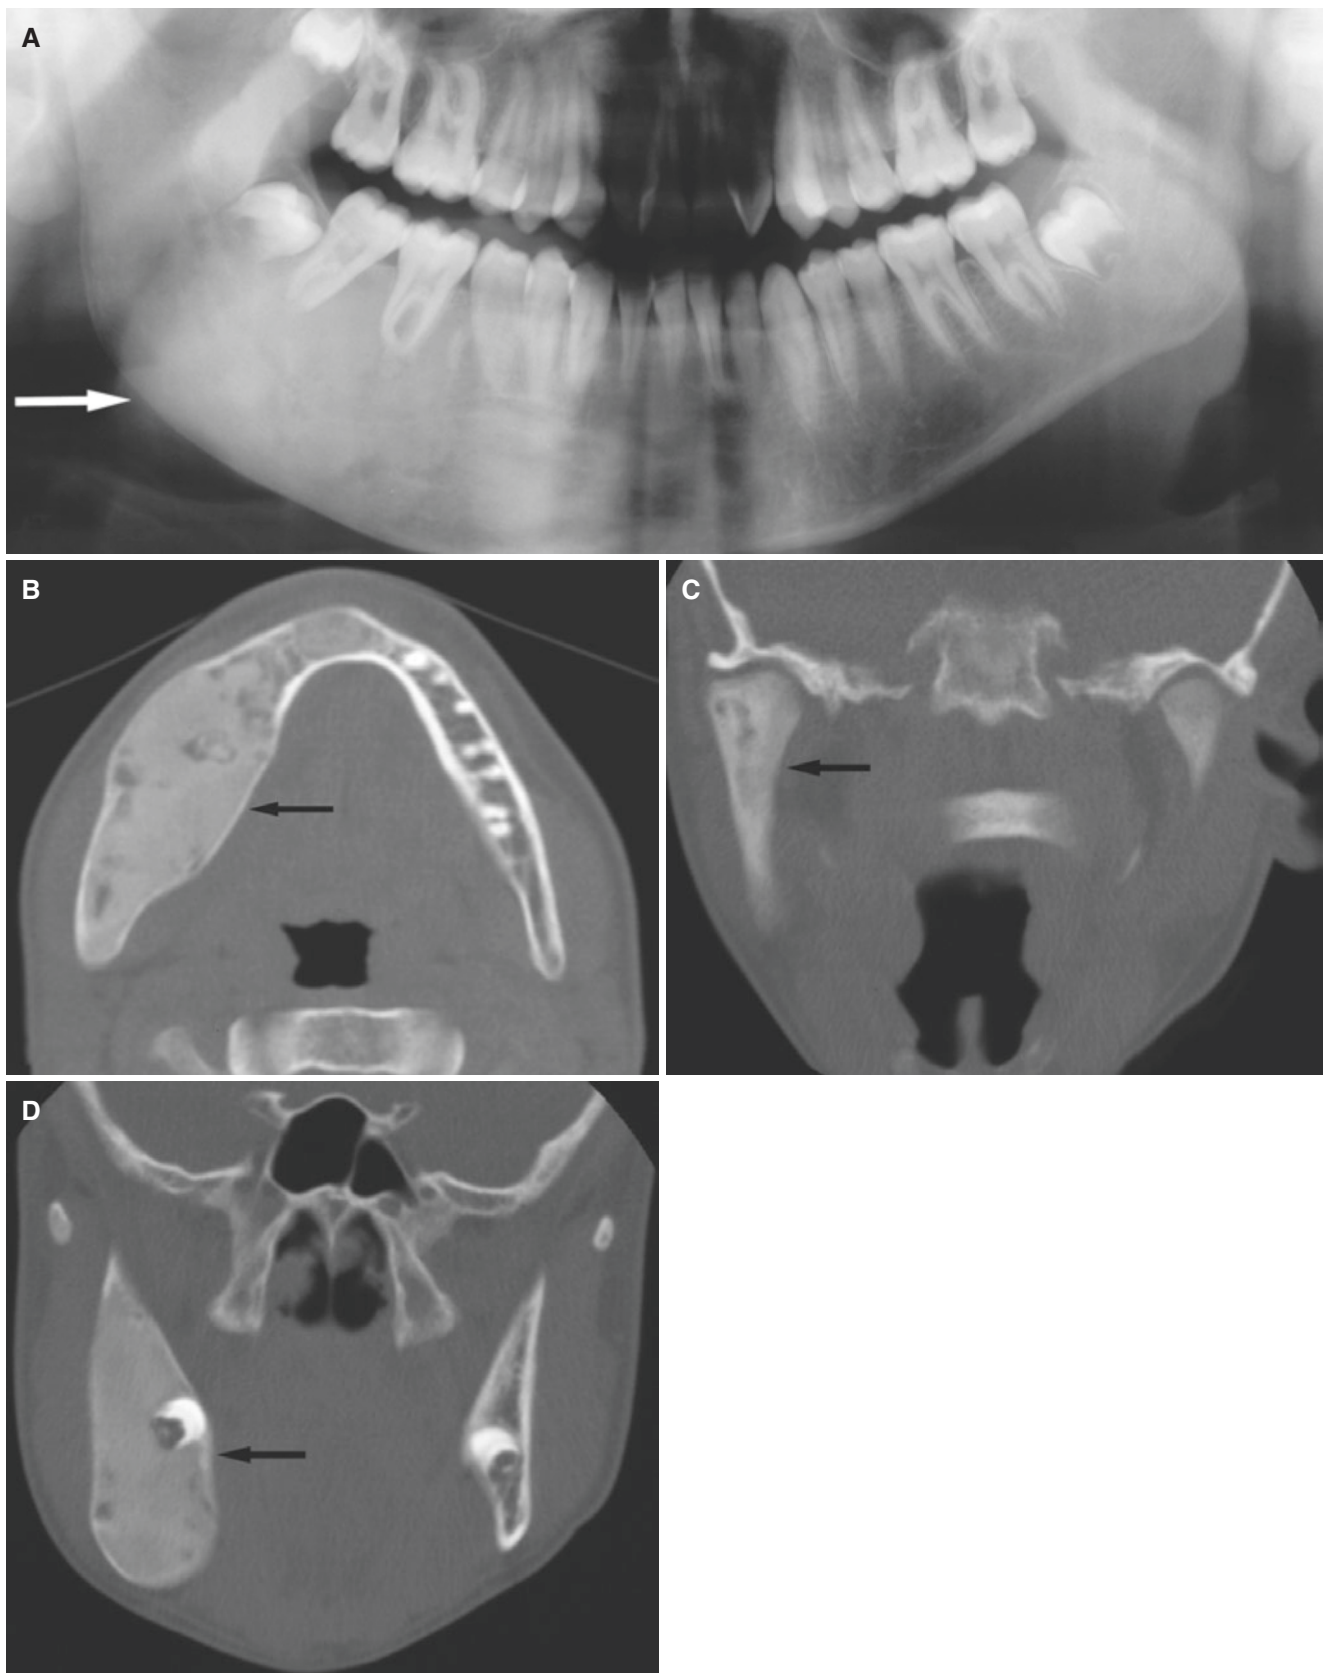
Fibrous dysplasia, mandible; 14-year-old male with painless facial asymmetry. (A) Panoramic view shows enlarged mandible with ground-glass appearance (*arrow*). (B) Axial CT image shows expanded mandible with ground-glass appearance (*arrow*). (C) Coronal CT
